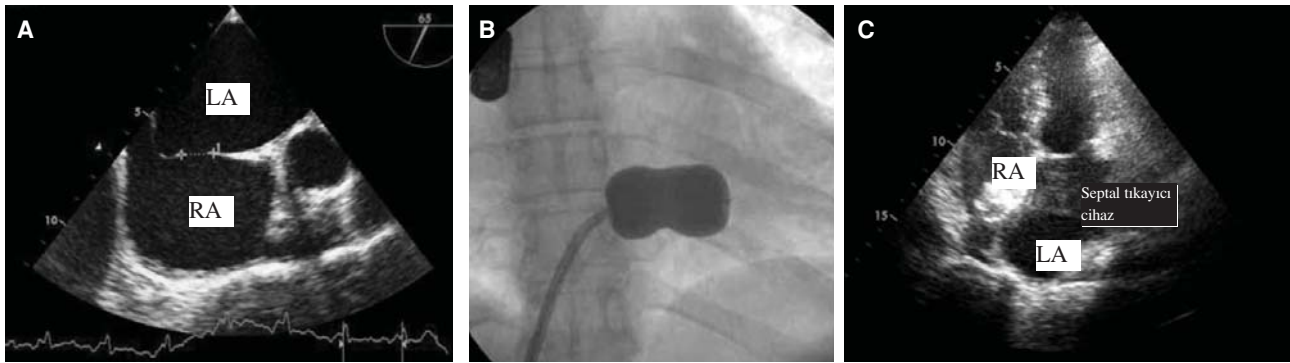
(A) Identification of the size of atrial septal defect on transesophageal echocardiography before percutaneous intervention. (B) Dilatation of the mitral valve with the Inoue balloon. (C) Image of the Amplatzer septal occluder device in the four chamber section on transthoracic echocardiography after percutaneous intervention.
